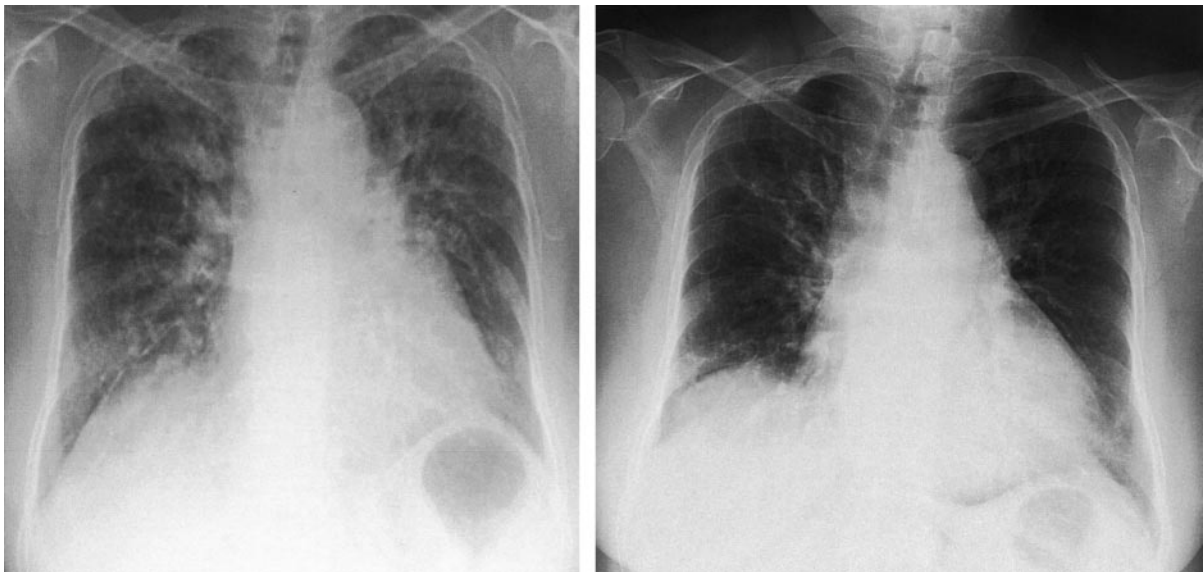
Chest radiograph at baseline (left) and at 4 weeks after corticosteroid treatment (right).
